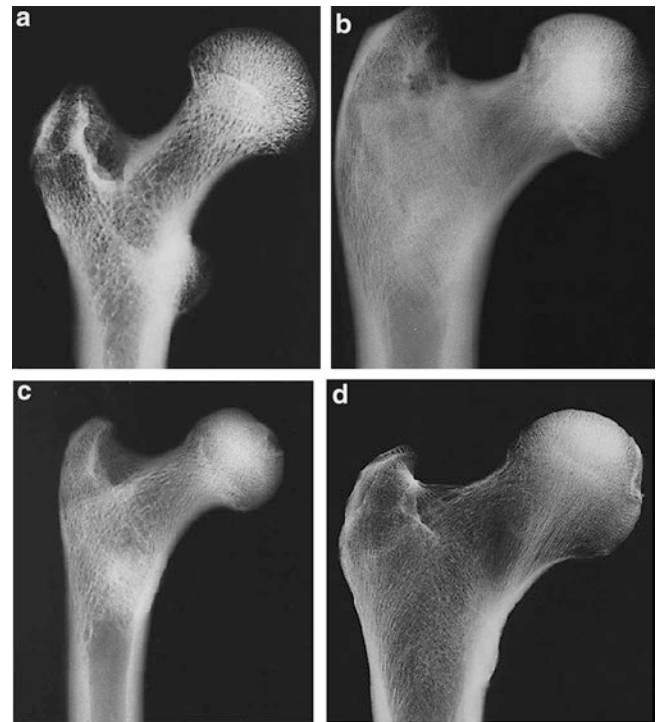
Radiographs of hominid hips with head-neck ratios (head largest diameter divided by smallest neck width). The human hip has the thickest neck, decreasing offset and impingement-free motion. Also note thicker cortical bone in the superior femoral neck of the apes (from Lovejoy 2005 [15], with permission). (a) Orangutan (1.8) (b) Gorilla (1.5) (c) Chimpanzee (1.5) (d) Homo (1.35). AP view, not to scale
